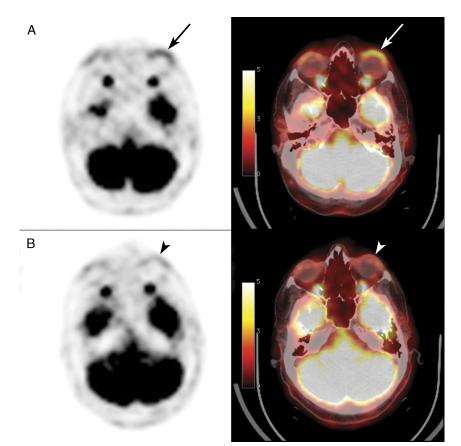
A, Baseline FDG PET/CT showing increased glucose analog in the left conjunctiva (arrow) as compared with the contralateral side (left-to-right SUV ratio, 3.0). B, Control after 3 of 6 cycles of chemotherapy showing an excellent metabolic response with normalized left-to-right SUV ratio to 1.0 (arrowhead).
